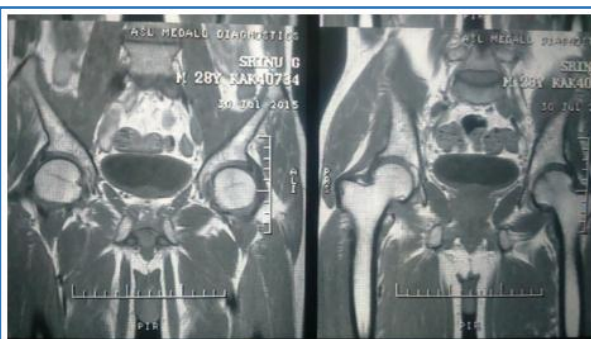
MRI images at the end of 18 weeks sagittal and axial cuts STIR images
